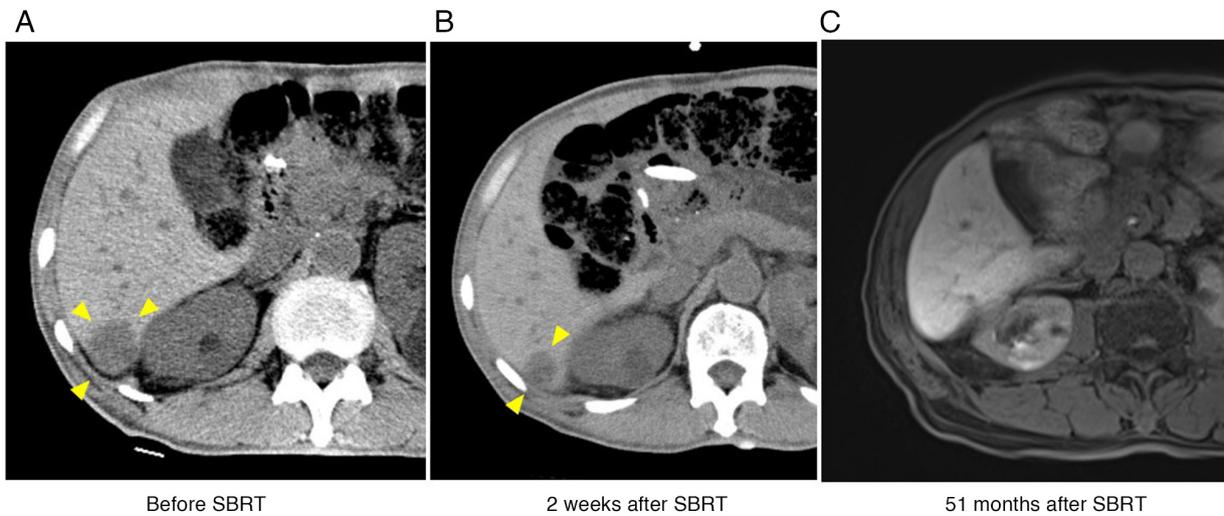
CT and MRI of the metastatic liver tumor. (A) CT revealed that the metastatic liver tumor showed no significant change in size after S-1-based chemotherapy despite the decrease in serum α -fetoprotein level. (B) The metastatic liver tumor showed partial response two weeks after the completion of SBRT. (C) MRI conducted 51 months after SBRT demonstrated sustained CR with partial liver atrophy in the irradiated field. Arrowheads indicate the metastatic tumor. CT, computed tomography; CR, complete response; MRI, magnetic resonance imaging; SBRT, stereotactic body radiotherapy.
